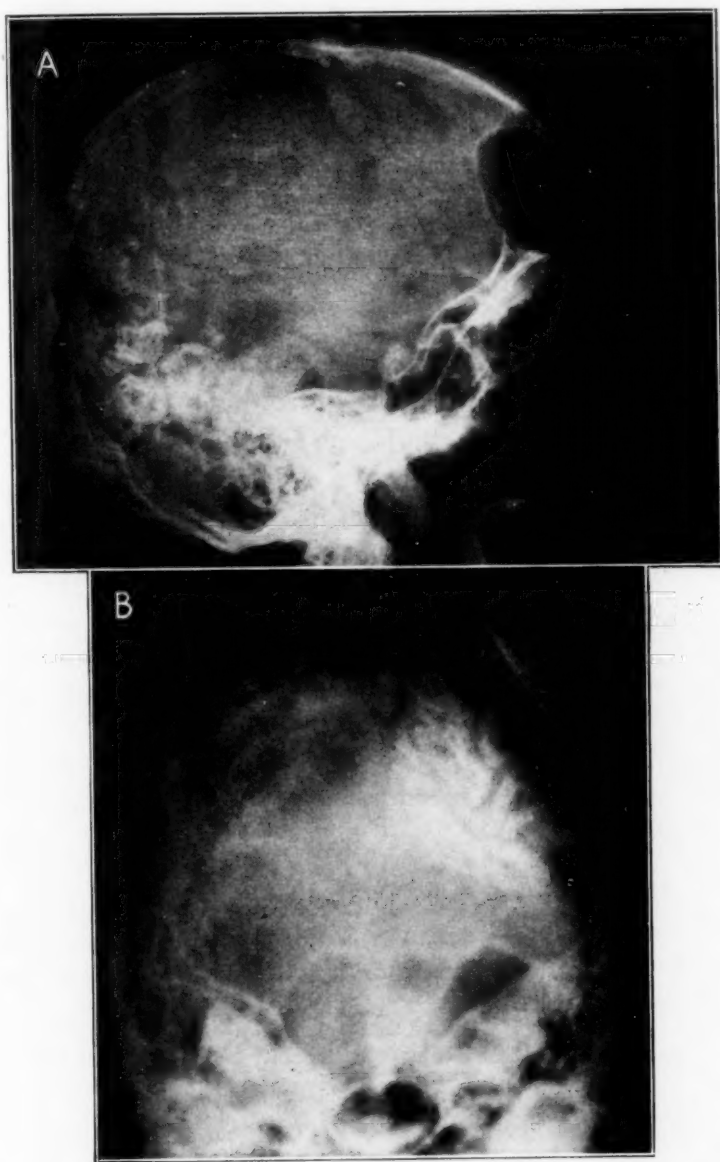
Roentgenograms taken at the age of 20. *A*, lateral view, showing the calcification essentially unchanged as compared with earlier films; *B*, roentgenogram showing the "angleworm" configuration.
